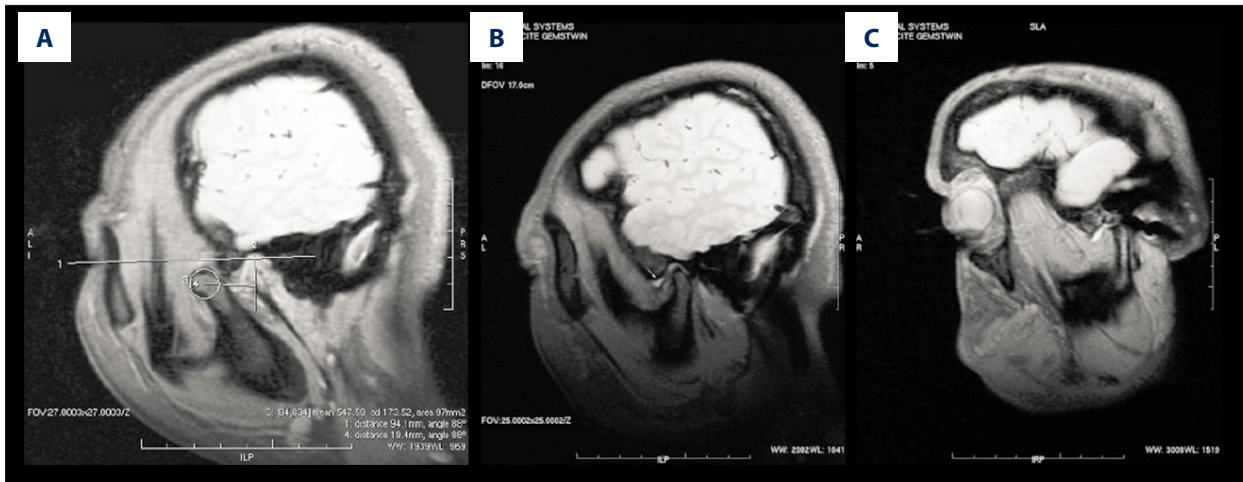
MRI analysis. (A) Condyle activity at the maximum opened-mouth position of ADDR patients. (B) At the closed-mouth position there is grade II high-density signal, showing “inverted triangle”. (C) Extensive effusion was observed at 1 side joint and distributed around the articular disc.
